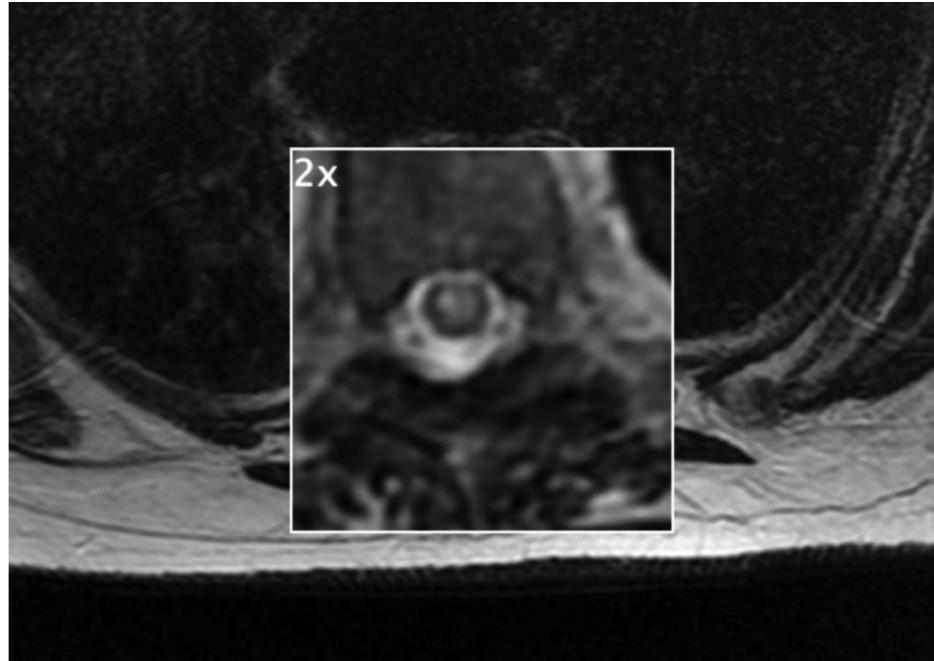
T2 FLAIR MRI of the thoracic spine showing an intradural, intramedullary hyperintensity consistent with transverse myelitis
